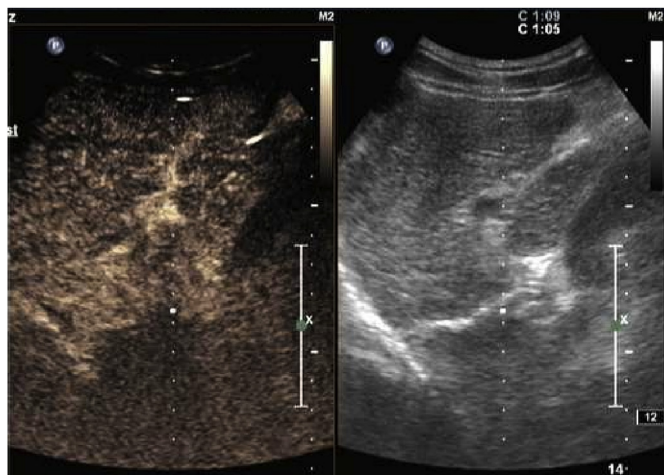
No blood flow signal was visible in the stent imaged with contrast-enhanced ultrasonography.
